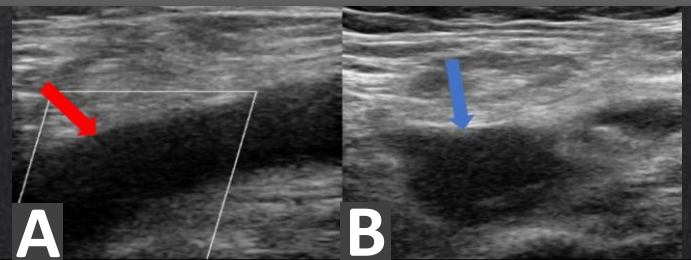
86-year-old woman presents with asymmetric edema of left leg. Left image shows absence of Doppler flow (A) - (red arrow) in the left common femoral vein. Right image demonstrate absence of compressibility (B) - (blue arrow) in this vein, compatible with acute thrombosis.
